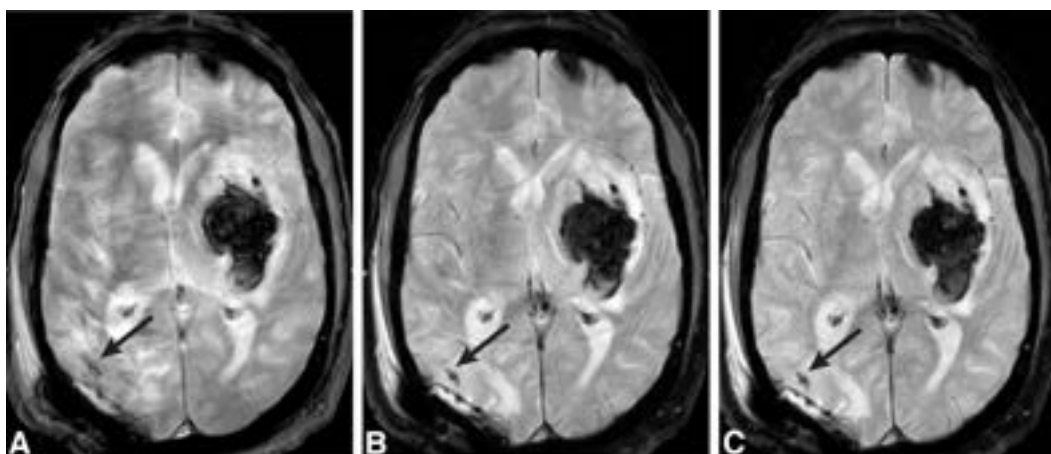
Axial MR images in a patient with a large left thalamic hemorrhage showing the effects of motion artifacts on standard GRE imaging (A) compared with non-motion-corrected (B) and motion-corrected (C) msEPI. Also note the increased conspicuity of a small parenchymal hemorrhage (arrow) in the right parietal region on msEPI compared with standard GRE. Reprinted with permission from the Barrow Neurological Institute, Phoenix, Arizona.
